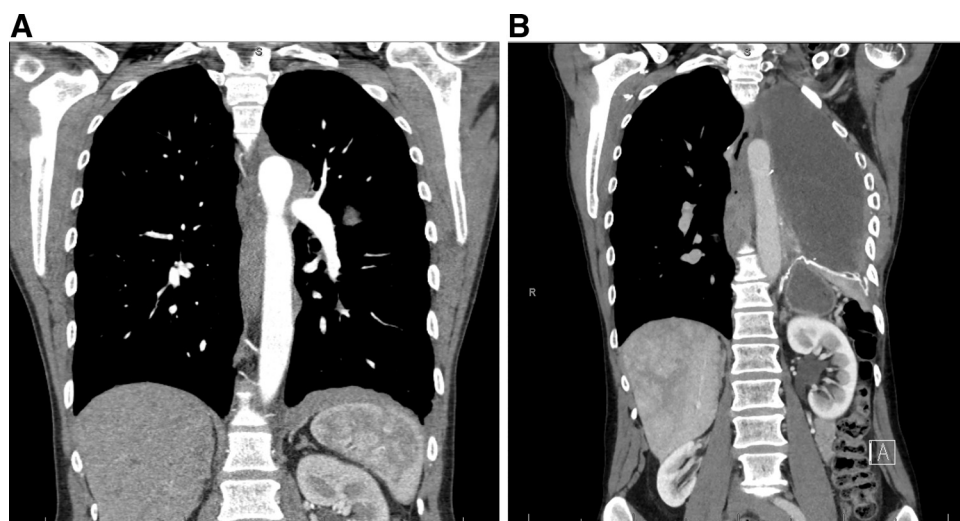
Computed tomography (CT) scans pre-EPP (left) and post-EPP (right). EPP, extrapleural pneumonectomy.
